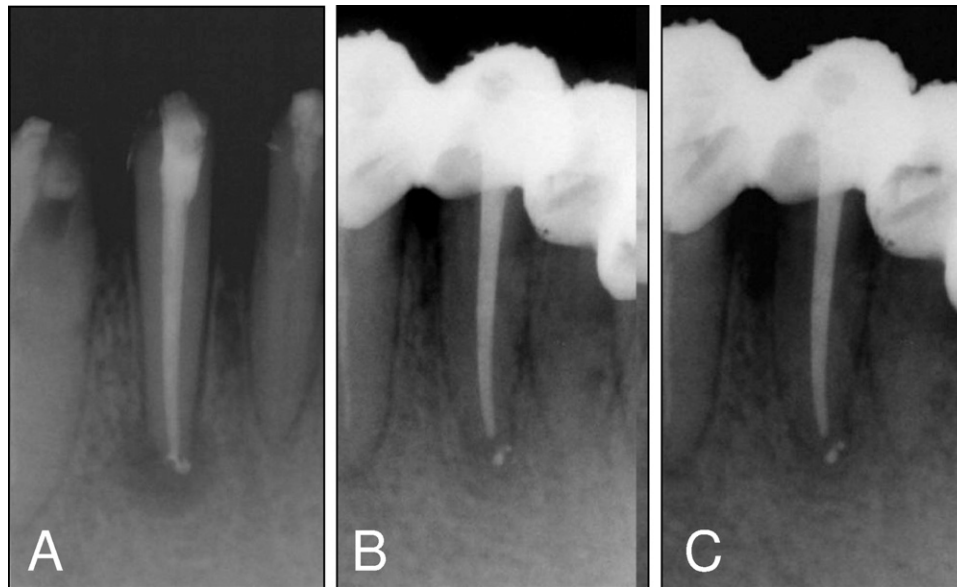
Healing of a periapical lesion after the Apexum procedure. (A) Immediate postoperative radiograph. (B) A follow-up radiograph at 3 months. (C) A follow-up radiograph at 6 months.
